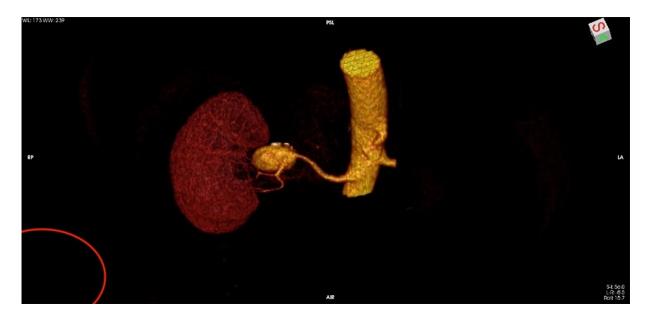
Volume rendering CT scan of RAA.
